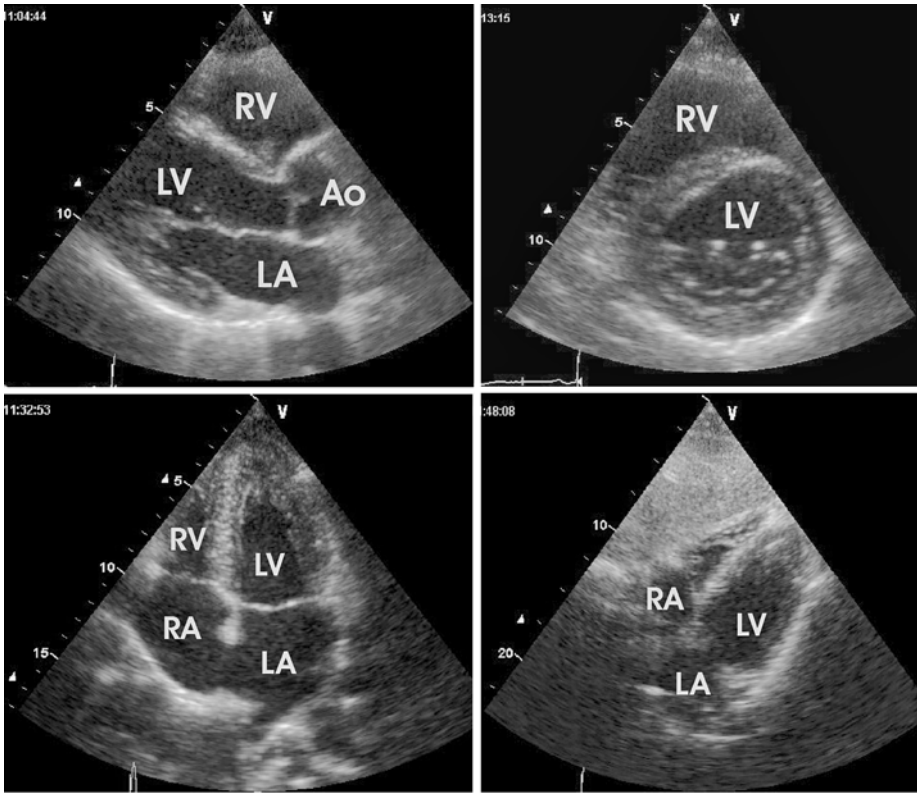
Standard transthoracic echocardiographic views. Upper left, parasternal long axis; upper right, parasternal short axis; lower left, apical four chamber; lower right, subcostal. Ao, aorta; LA, left atrium, LV, left ventricle, RA, right atrium, RV, right ventricle.
